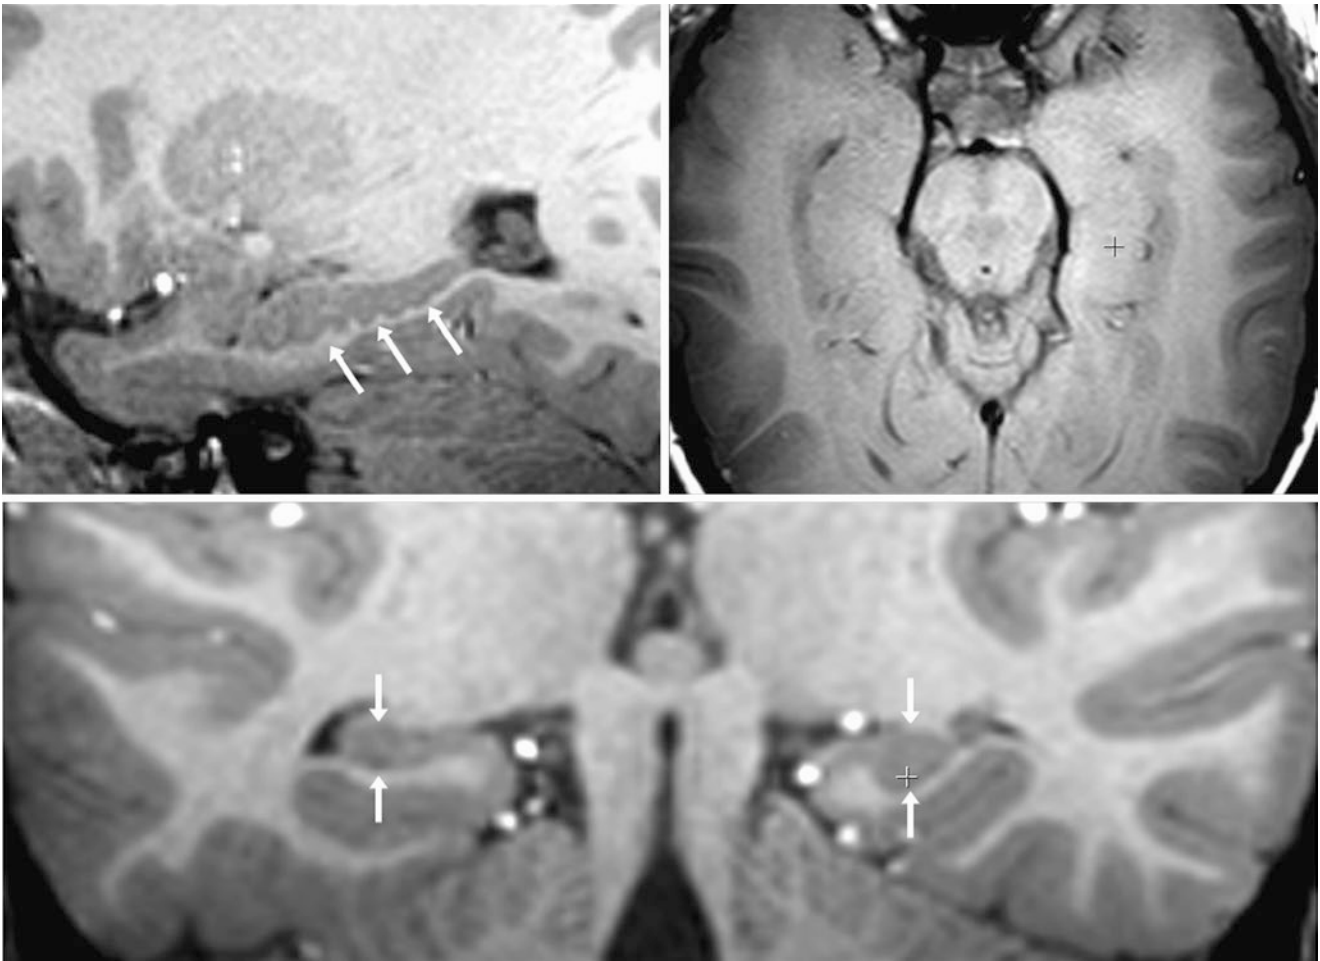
A 7 year old whose images showed a corrugated appearance of the left hippocampus (arrows) on a 3 T MRI with a 1-mm thin sagittal T1WI of the left side (top left). Axial (top right) and coronal
